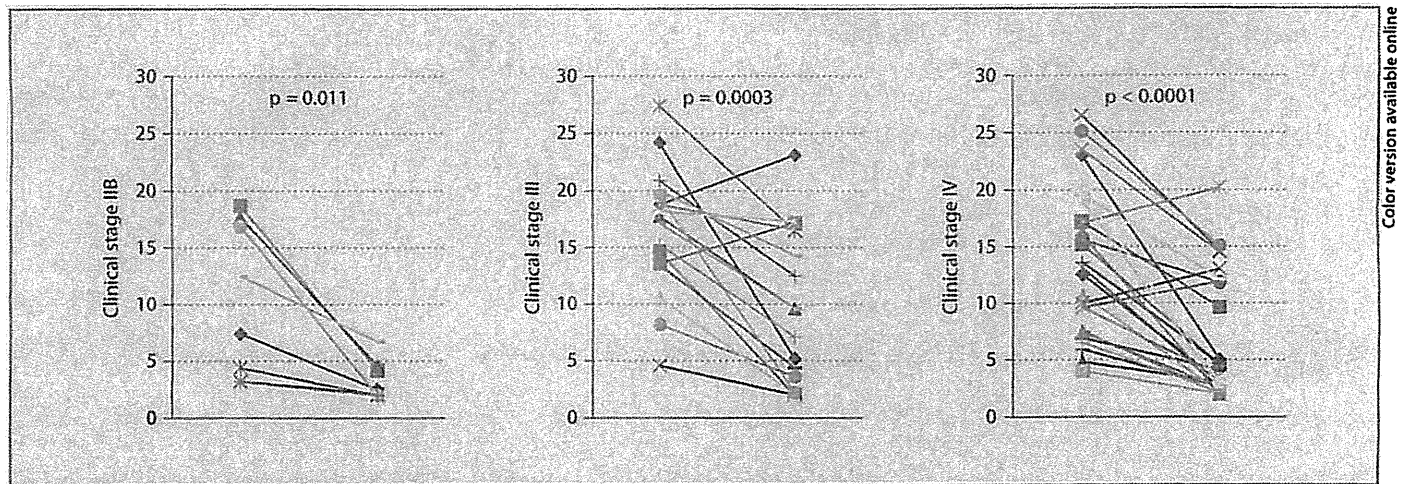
Changes in SUV during induction chemotherapy in the primary esophageal tumors. Significant decrease in SUV was observed by induction chemotherapy, irrespective of the staging.
